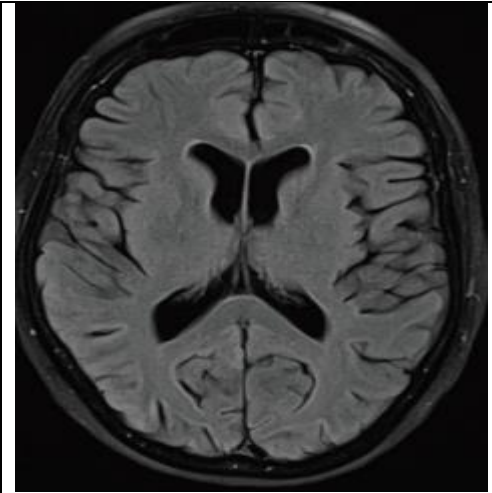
Magnetic resonance imaging of the patient's brain shows minimal FLAIR changes
